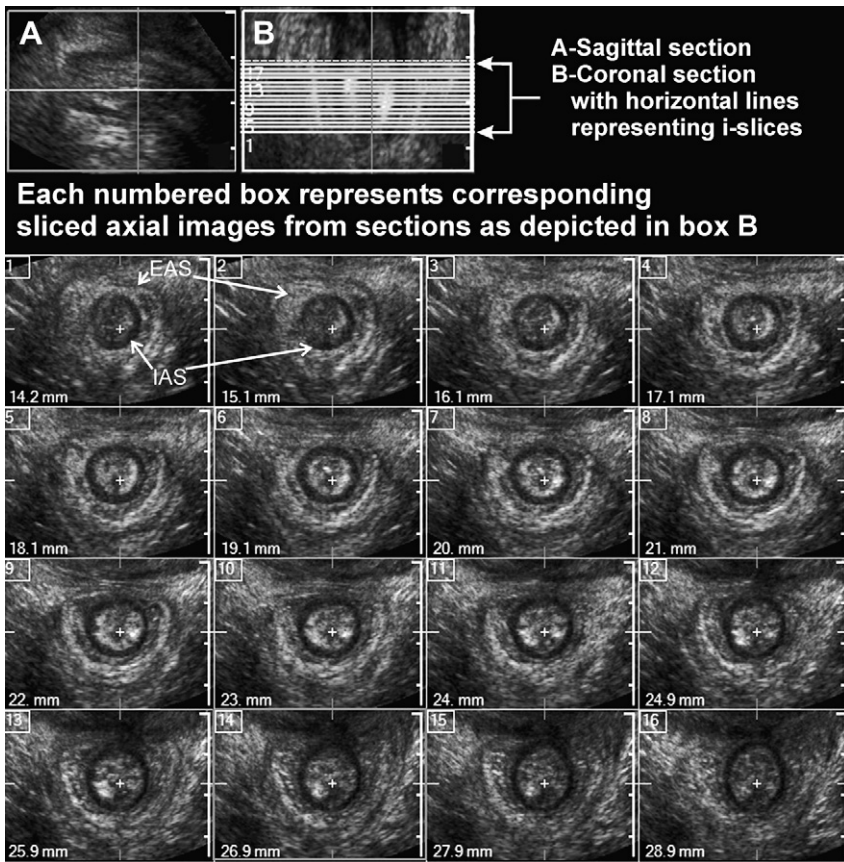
Ultrasound images of the anal canal obtained from the 3D-US volume: cross-sectional (axial) images along the length of anal canal in a nulliparous subject. In this example the anal sphincter complex is shown at every 1 mm distance using I-Slice function of HD-11 (Philips). Marked in the figure are the IAS (black circle) and the EAS (white outer ring) are smooth, uniform and symmetrical. Obtained from author.
